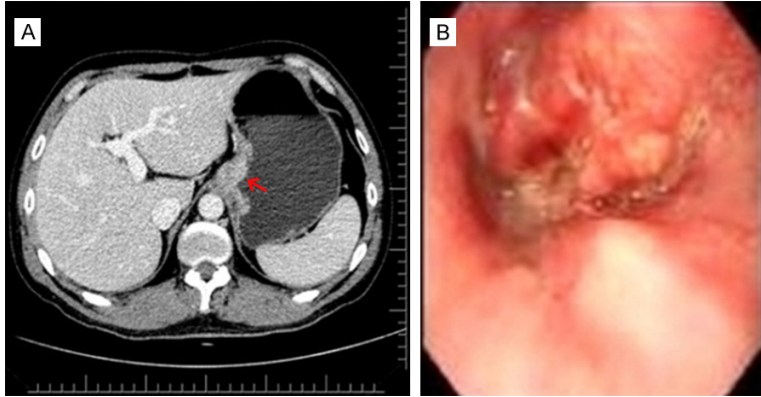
Mucosal destruction and stomach wall rigidity as indicated by the red arrow in the CT scan (A) and the gastroscopy image (B), showing a large irregular mass at gastric cardia and gastric body.
